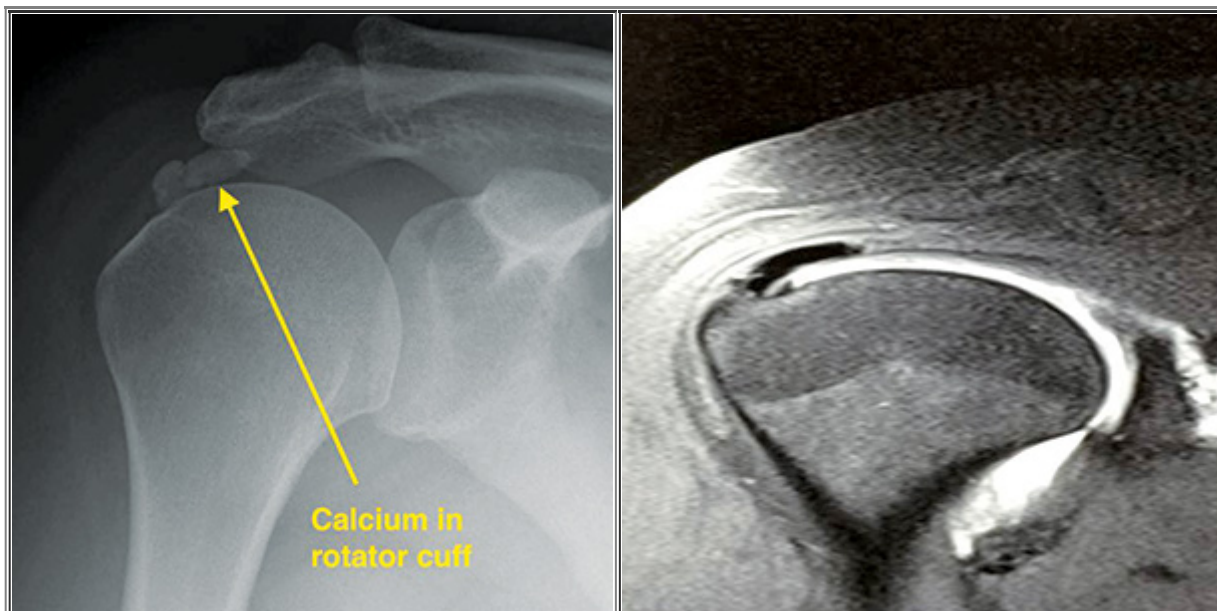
X-ray showing calcific deposits (white) in rotator cuff.
